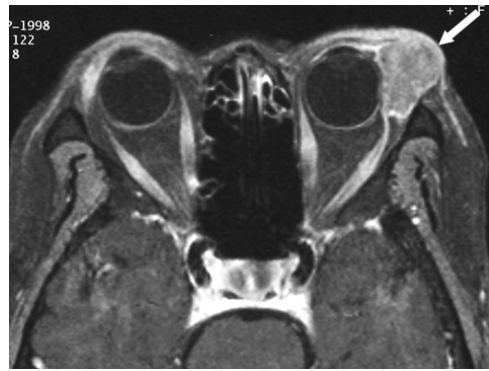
Squamous cell carcinoma of the conjunctiva in an upper eyelid of a 61-year-old man. A gadolinium enhanced T1-weighted axial image shows a well-enhanced lobulated mass in the superior lateral aspect of the left eye globe (arrow). The thickened skin is not separable from the mass.
